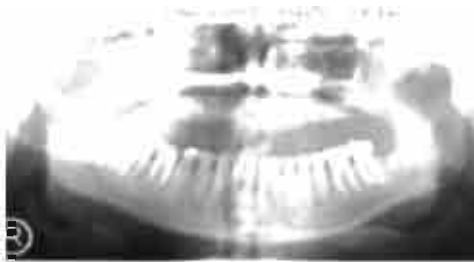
Preoperative Orthopantomogram showing radiolucency in anterior maxillary region.
